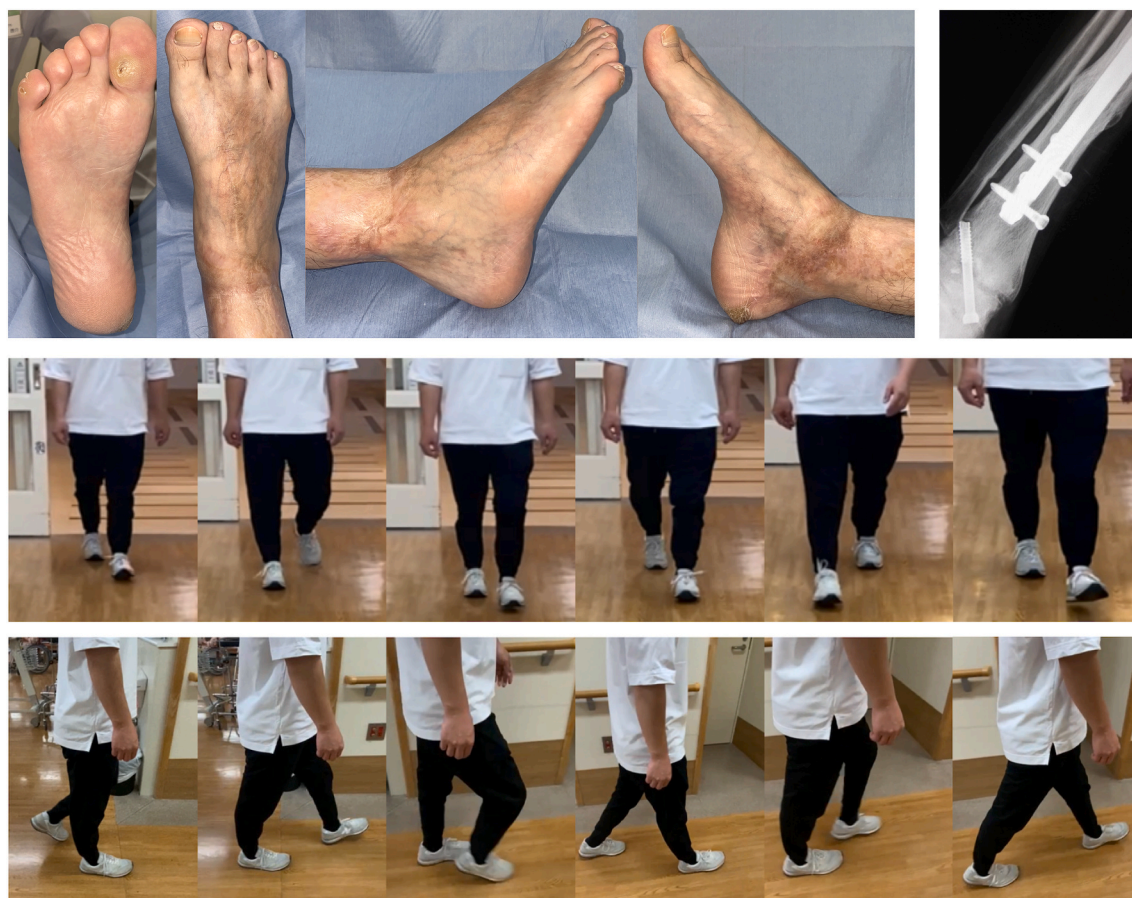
Real-life images and X-ray images at the time of final observation.
